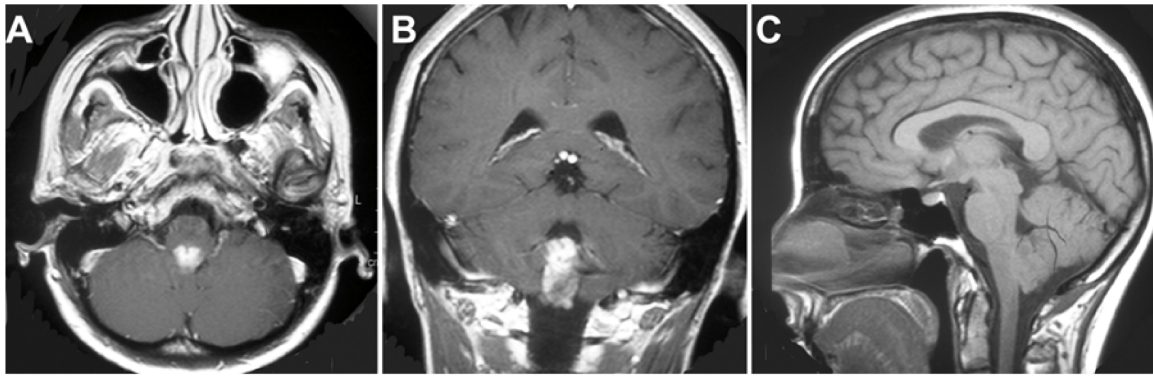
Axial (A), coronal (B), and sagittal (C) magnetic resonance imaging with gadolinium revealed a fourth ventricular tumor originating from the medulla.
